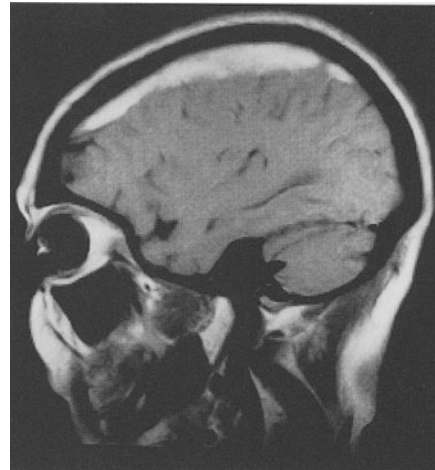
T1-weighted MR (TR 650, TE 25) demonstrating a subdural hematoma. (Image from a 0.3-T Hitachi open MR system)
